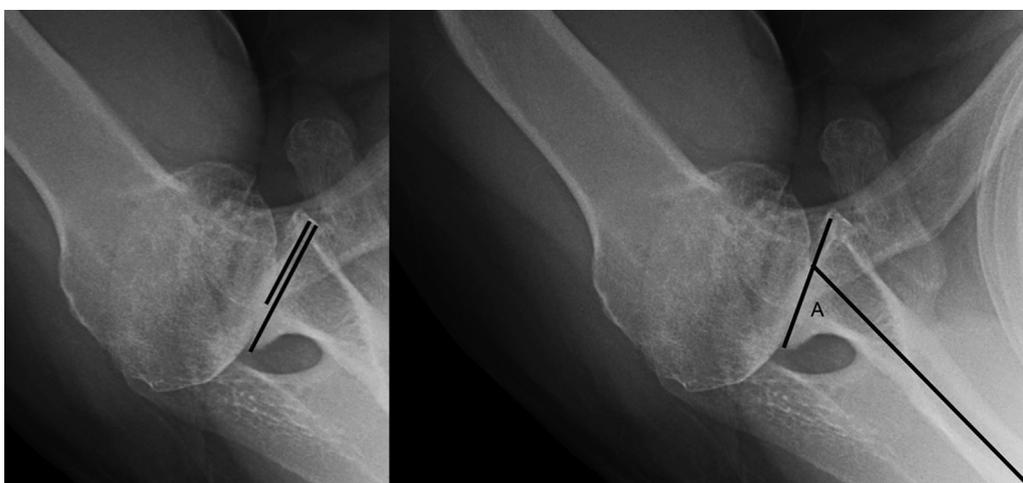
Measurements on the standardized axillary radiograph. The contact position ratio (*left*) is the ratio of the distance from the anterior glenoid lip to the point of humeral contact on the glenoid (*short line*) divided by the distance from the anterior to the posterior lip of the glenoid (*long line*); a ratio of 0.5 indicates that the humeral contact point is centered on the glenoid, whereas ratios >0.5 indicate posterior decentering. The glenoid retroversion (*right*) is 90° minus the angle A between the plane of the scapula (*long line*) and the plane of the glenoid face (*short line*).
